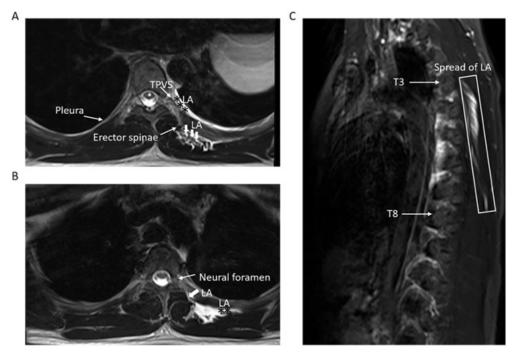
Magnetic resonance imaging of Case 1 after combined TPVB and ESPB. (A) Axial T2-weighted fluid-sensitive magnetic resonance imaging at the vertebra, where local anesthetic can be detected inside the left paravertebral space (black asterisk) and the ESM fascial plane (bold arrow). (B) Axial view of the vertebra. The injectate was detected spreading into the intercostal space (black asterisk) and in route to the neural foramen (bold arrow). (C) Sagittal T2-weighted fluid-sensitive magnetic resonance imaging of the thoracic vertebra, where the local anesthetic can be detected in the fascial plane beneath the erector spinae muscle from the T3 to T8 vertebra (rectangular box). TPVB, thoracic paravertebral block; ESPB, erector spinae plane block; PVS, paravertebral space; LA, local anesthetic; ESM, erector spinae muscle.
